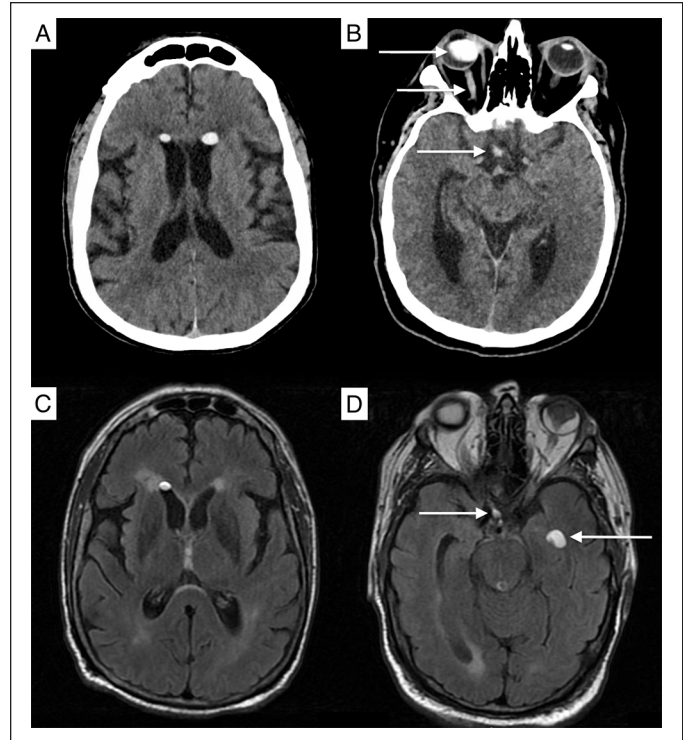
Neuroimaging at second presentation, 53 months postoperatively. (A) Computed tomography of the brain in supine positioning with axial slices shows hyperdense material within the anterior horns of the left and right lateral ventricles. (B) Hyperdense silicone oil (SO) is also seen in the right globe, right optic nerve, and right side of the optic chiasm. A new left retinal hemorrhage is also noted on a separate slice (not presented). (C) Magnetic resonance imaging (MRI) of the brain 5 days later in supine positioning. Axial T2-weighted fluid-attenuated inversion recovery sequence shows SO within the right lateral ventricle. The lesion in the anterior horn of the right ventricle measures 7×4 mm axially. (D) The lesion in the left lateral ventricle has migrated from the anterior horn to the temporal horn and measures 12×8 mm axially. There is no adjacent increased T2 signal to suggest an associated inflammatory process. Additionally, there is high T2 signal within the proximal right optic nerve and dependent high T2 signal at the right optic chiasm. The signal of the material within the ventricles, the right optic nerve, and the optic chiasm matches the signal of the material within the right globe. Multiple foci of acute cerebral ischemia are present, in keeping with further embolic stroke. Additionally, the ventricles and cerebrospinal fluid-filled spaces are enlarged, in keeping with generalized parenchymal loss.
